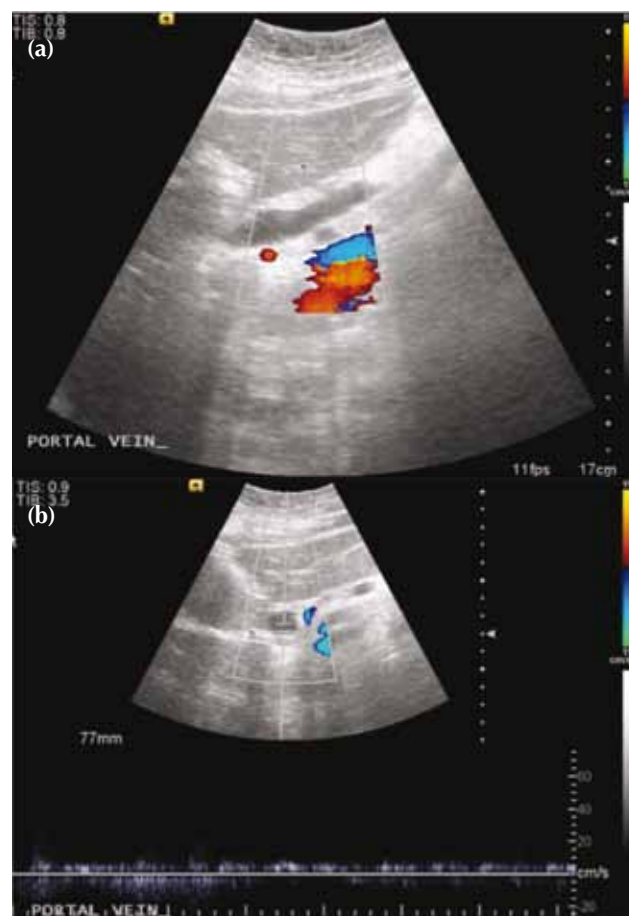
Figure Portal vein thrombosis is indicated by (a) lack of significant colour flow within the vein on Doppler ultrasonography and (b) minimal flow within the vein on spectral Doppler ultrasonography.
